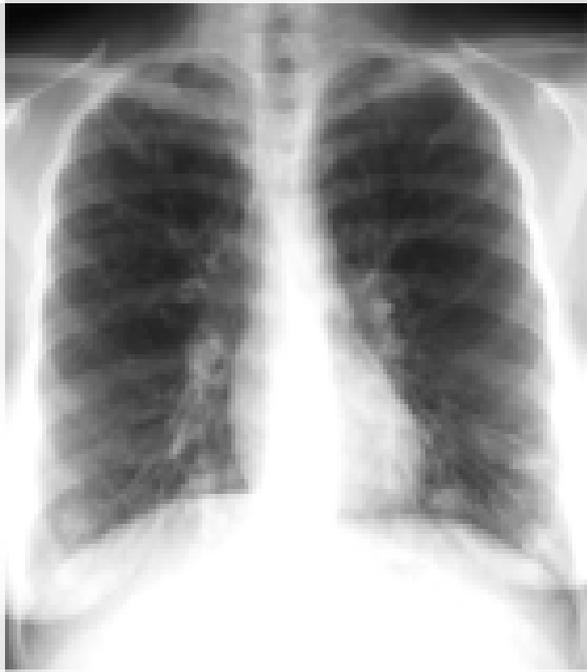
PA chest radiograph.
